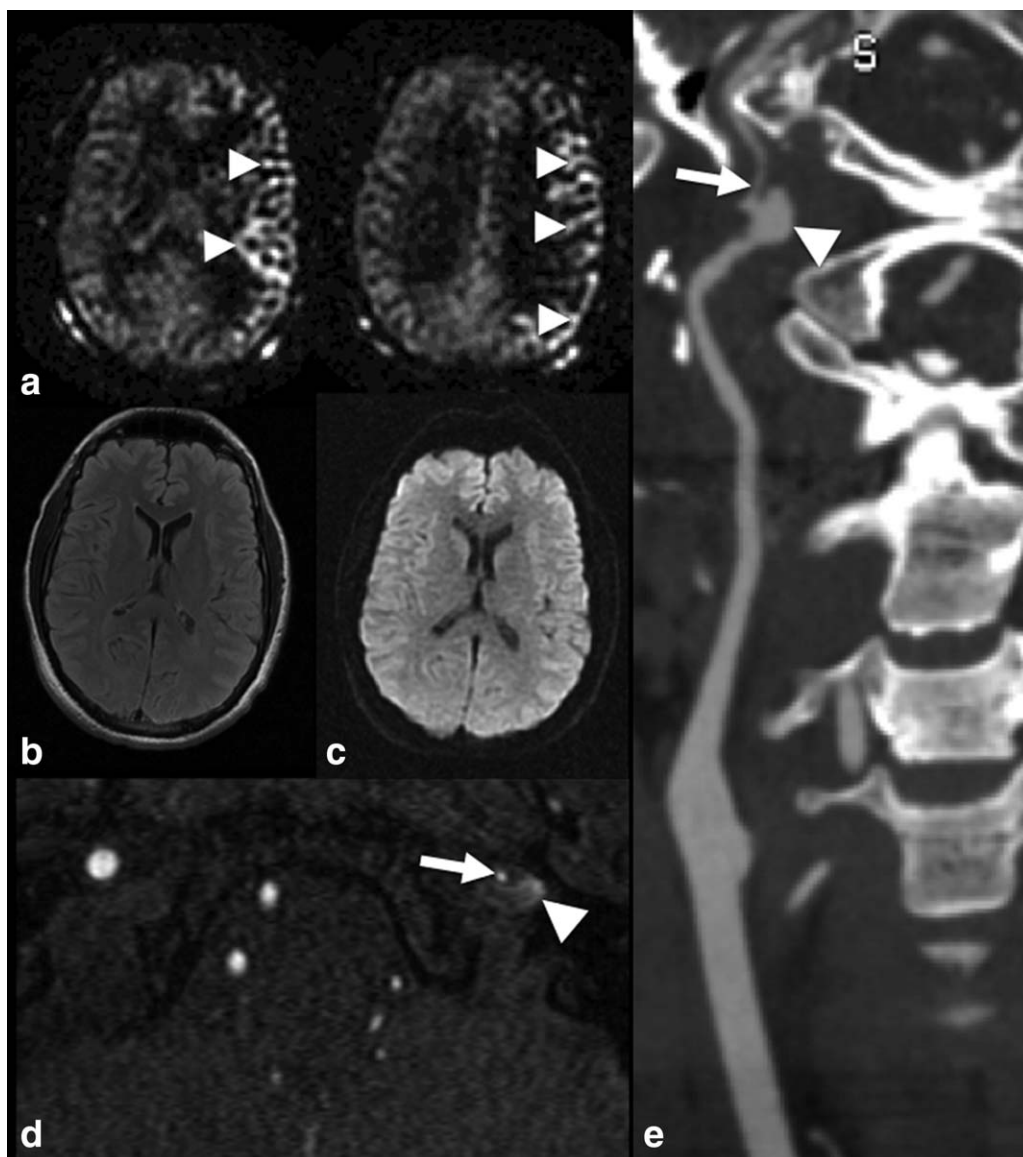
Arterial transit artifact (ATA) in a 35-year-old man with a flow-limiting left ICA dissection. a: Serpiginous high signal is seen on the ASL CBF maps, reflecting persistence of labeled spins in the left middle cerebral artery Sylvian branches (arrowheads), due to increased transit time through the dissected left ICA. The parenchymal CBF appears low; however, this is artifactual, as labeled spins have not yet reached the parenchymal capillary bed. b: FLAIR and (c) diffusion-weighted imaging show no parenchymal abnormality. d: TOF MRA source image at the level of the carotid canal demonstrates a left ICA pseudoaneurysm (arrowhead) associated with the dissection, with diminished flow within the lumen (arrow). e: Curved planar reformatted image of the left ICA from the CT angiogram confirms a flow limiting dissection, with pseudoaneurysm (arrowhead) and marked narrowing of the lumen distal to this (arrow).
